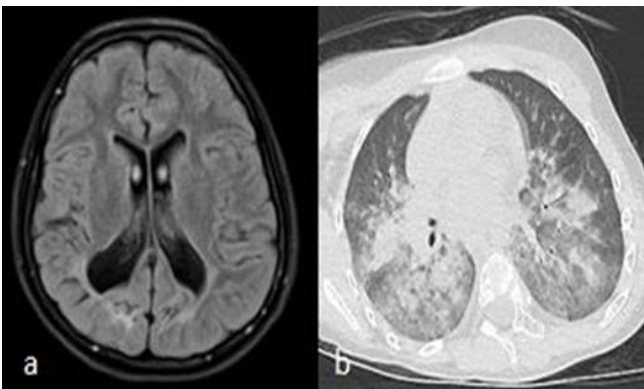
a- Cortical atrophy and gliosis in subcortical white matter in FLAIR sequence of a 12-year-old female patient, b- Axial non-contrast thorax CT shows bilateral diffuse parenchymal infiltrates secondary to COVID-19 in the same patient
